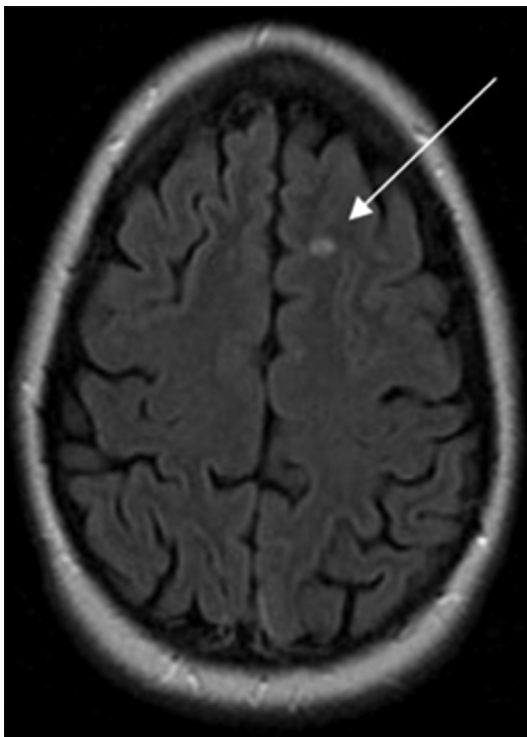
Brain MR imaging of a patient with frequent migraines who had white matter lesions. Arrow identifies white matter lesion visible on FLAIR axial image.
